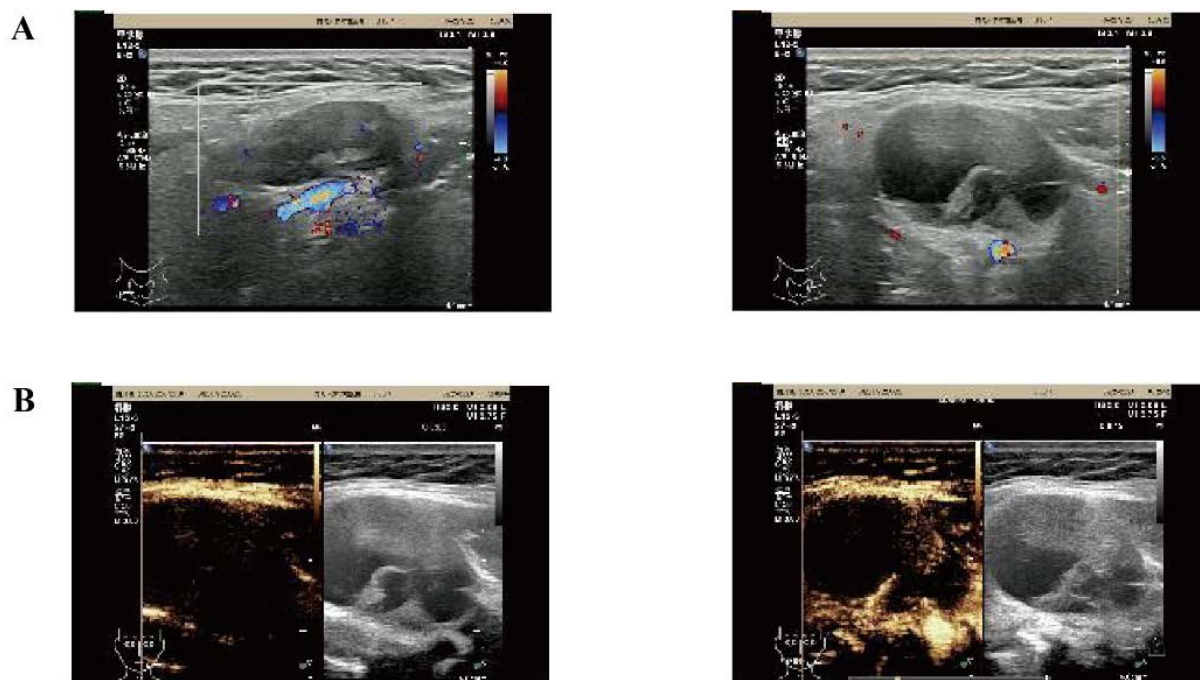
Ultrasound examination
